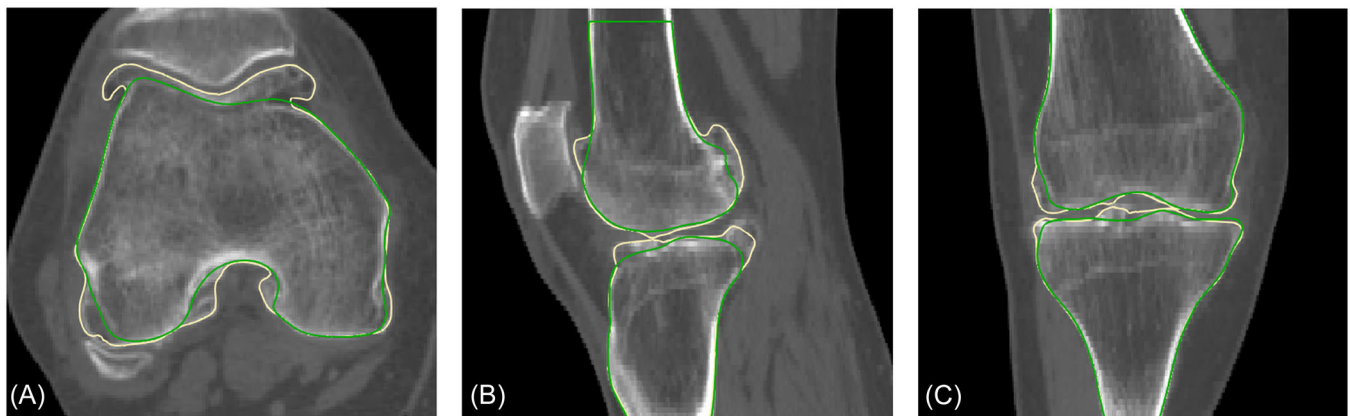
Computed tomography (CT) scan in axial (A), sagittal (B), and coronal (C) view of a single patient's knee depicting segmentation of the femoral and tibial osteophytic bones (yellow lines) and identification of the preosteophytic bone boundaries after removal of osteophytes (green line).
